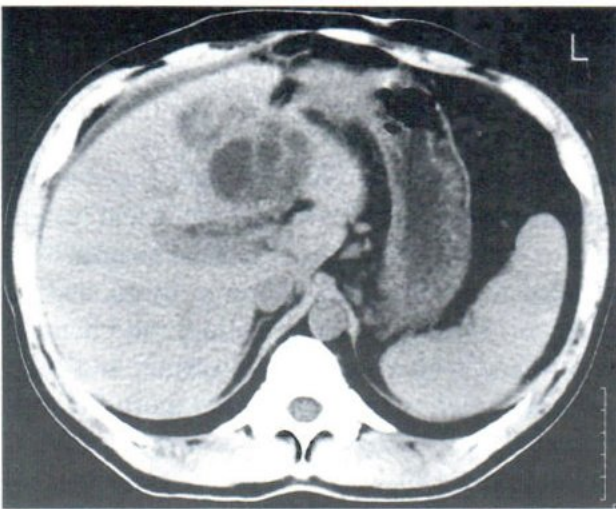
CT scan of the liver revealed a cluster of small, low density areas in subhepatic region of left lobe with tract like fashion (arrow). Minimal free fluid was seen at anterior aspect of the liver (arrowhead).
